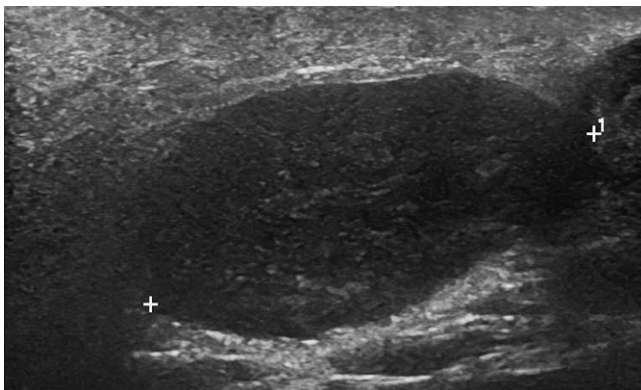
The gray scale sonographic image shows a solid, hypoechoic, homogeneous lesion in the parotid gland, a Warthin's tumor.
